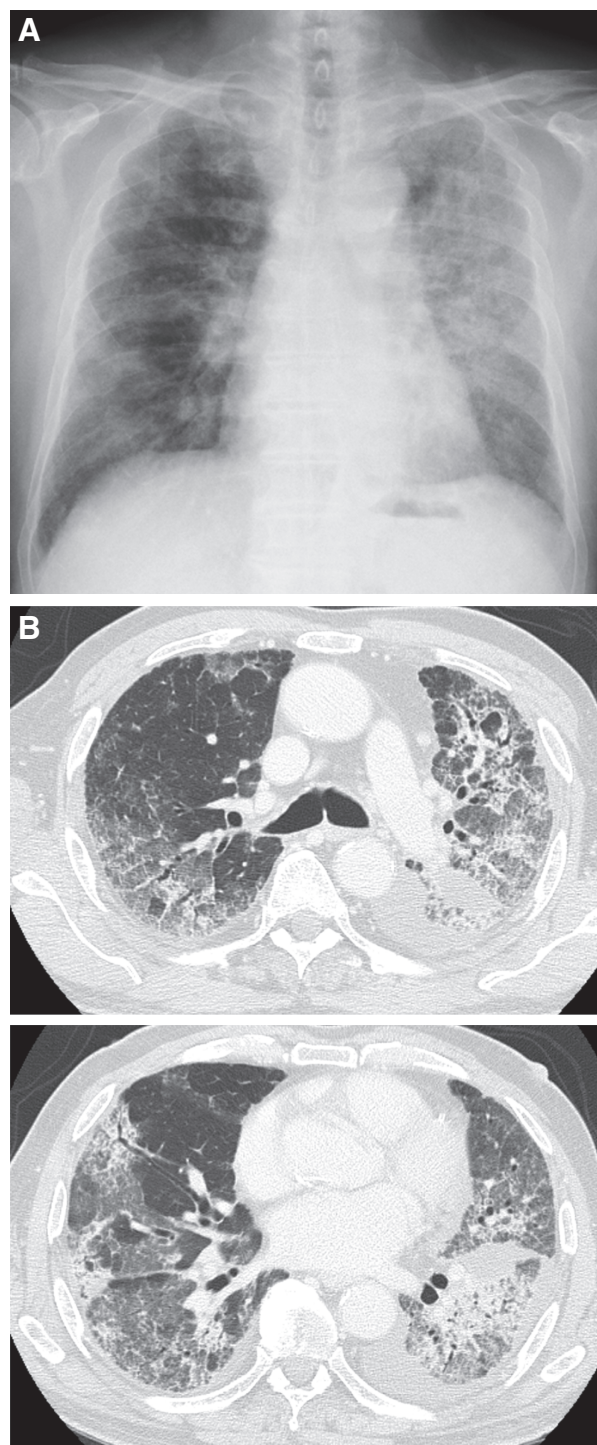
Chest radiological findings. (A) Chest radiographic findings on admission show diffuse ground glass opacity (GGO). (B) Chest high-resolution computed tomography findings on admission demonstrate diffuse subpleural GGO with traction bronchiectasis and slight pleural effusion.
